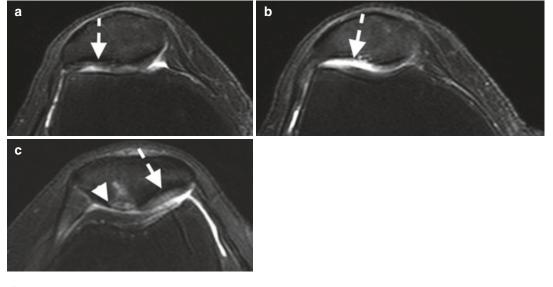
MRI axial T2 of the patellofemoral articulation. (a) Lateral facet cartilage loss with areas greater than and less than 50 % loss (*dashed arrow*), (b) full-thickness cartilage loss of the lateral facet, (c) full-thickness cartilage
